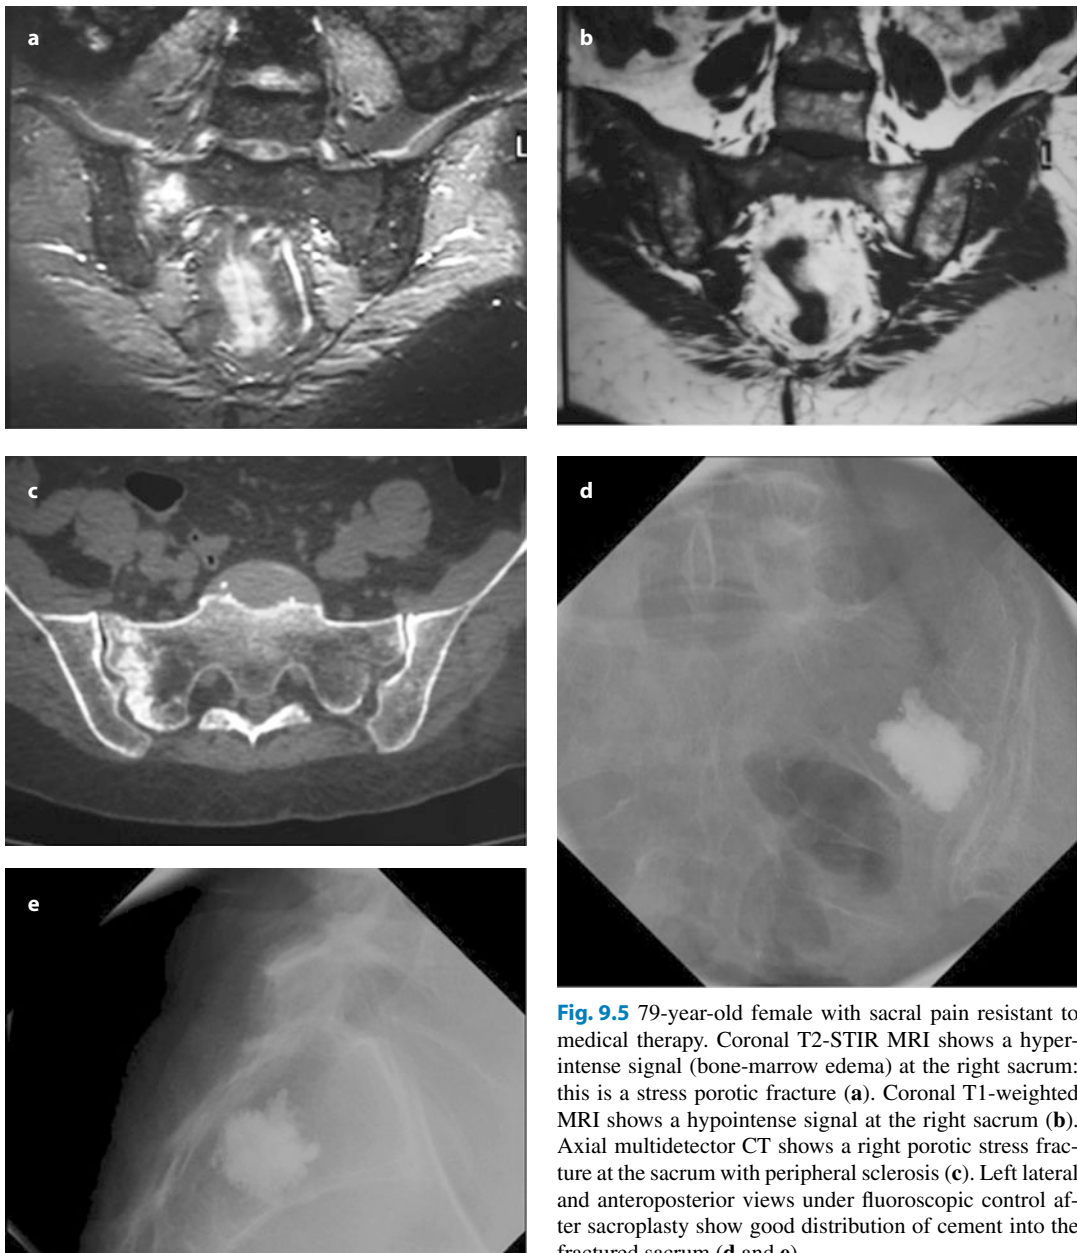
79-year-old female with sacral pain resistant to medical therapy. Coronal T2-STIR MRI shows a hyperintense signal (bone-marrow edema) at the right sacrum: this is a stress porotic fracture (a). Coronal T1-weighted MRI shows a hypointense signal at the right sacrum (b). Axial multidetector CT shows a right porotic stress fracture at the sacrum with peripheral sclerosis (c). Left lateral and anteroposterior views under fluoroscopic control after sacroplasty show good distribution of cement into the fractured sacrum (d and e)
